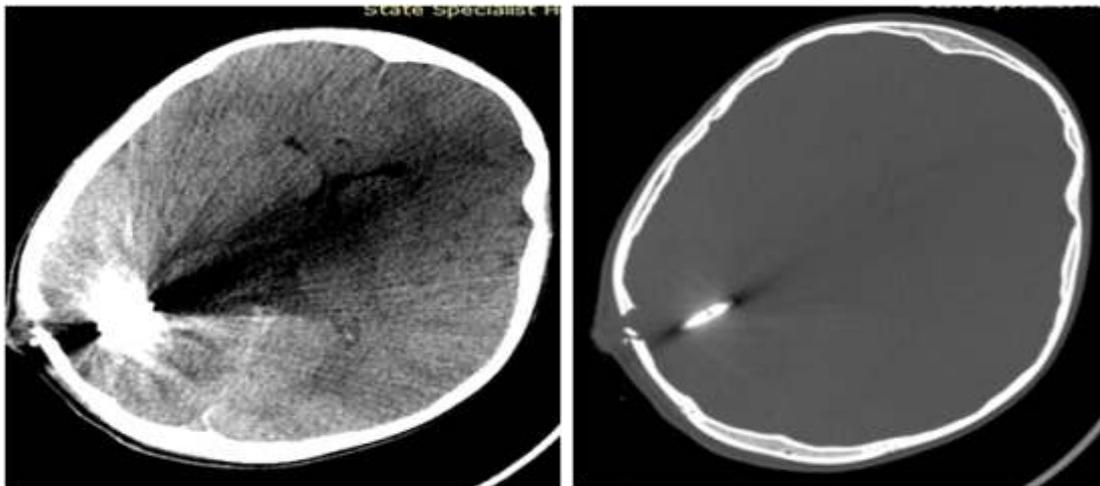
Axial CT Brain showing parieto-occipital bullet (brain and bone windows respectively)
